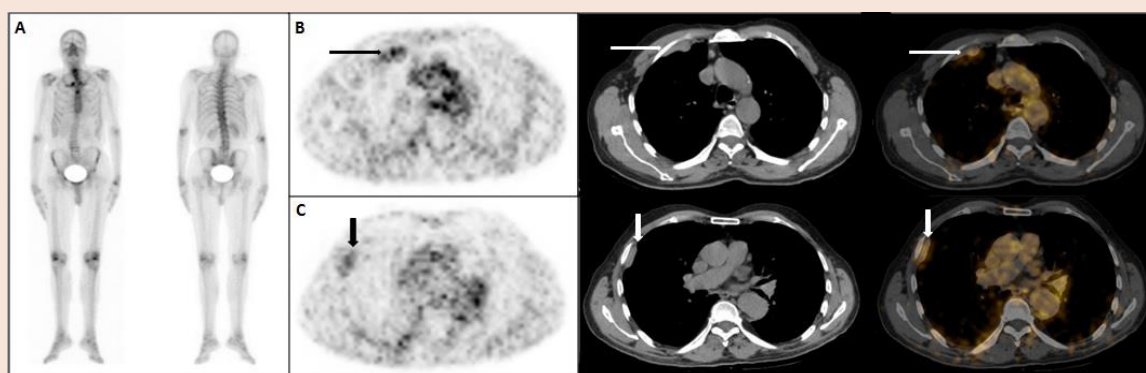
Suspicious Tc-99m MDP uptake was seen on right hemithorax on bone scintigraphy images and the patient was admitted to ⁶⁸Ga-PSMA PET/CT. Slightly increased uptake, corresponding to pleural thickening seen on the CT images (first intercostals space (Figure 1B) and neighbourhood of the 4 and 6 rib (Figure 1C), was seen in the right hemithorax on Ga-68 PSMA PET/CT images.
